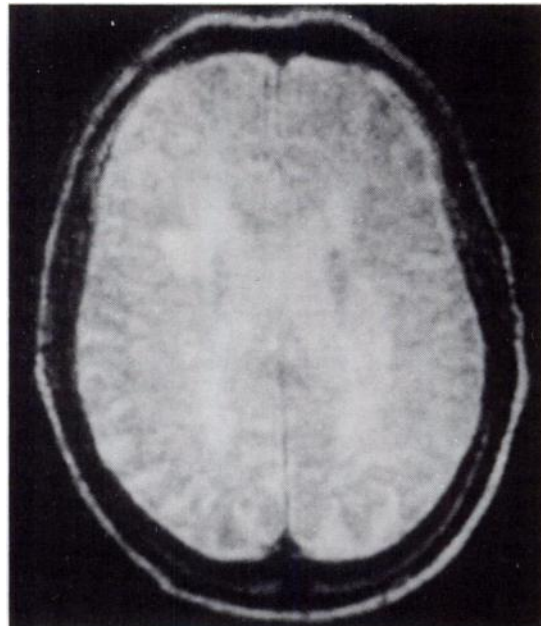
T<sub>2</sub>-weighted MRI scan from case 2 shows increased signal in subfrontal, subparietal, and suboccipital white matter.
